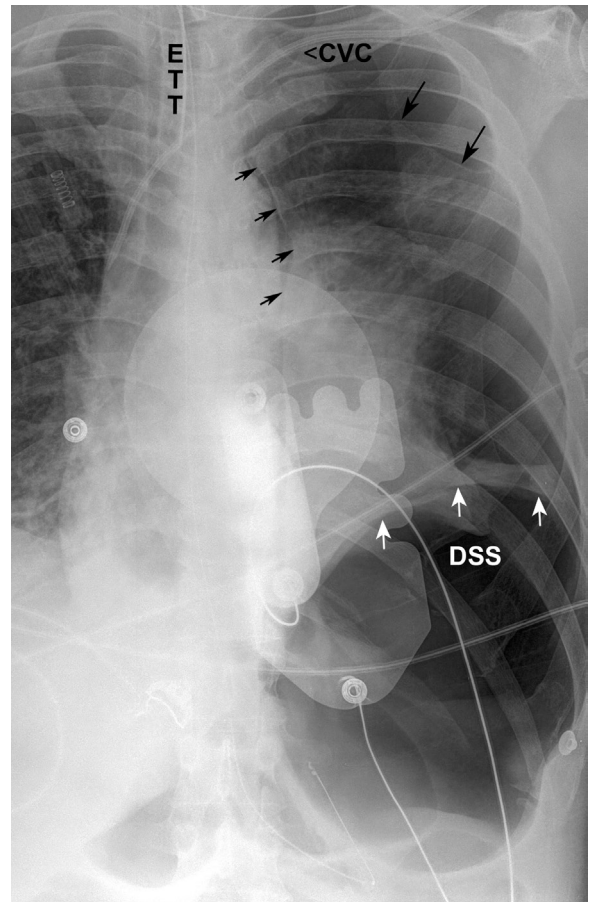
■ Anteroposterior (AP) supine chest x-ray. Large left-sided pneumothorax (PTX) with air noted around the left lung apex (large arrows), medially along the mediastinum (small arrows), and inferiorly, under the lung (white arrows). The latter results in the so-called “deep sulcus sign” (DSS) because costophrenic and cardiophrenic angles can be seen.
